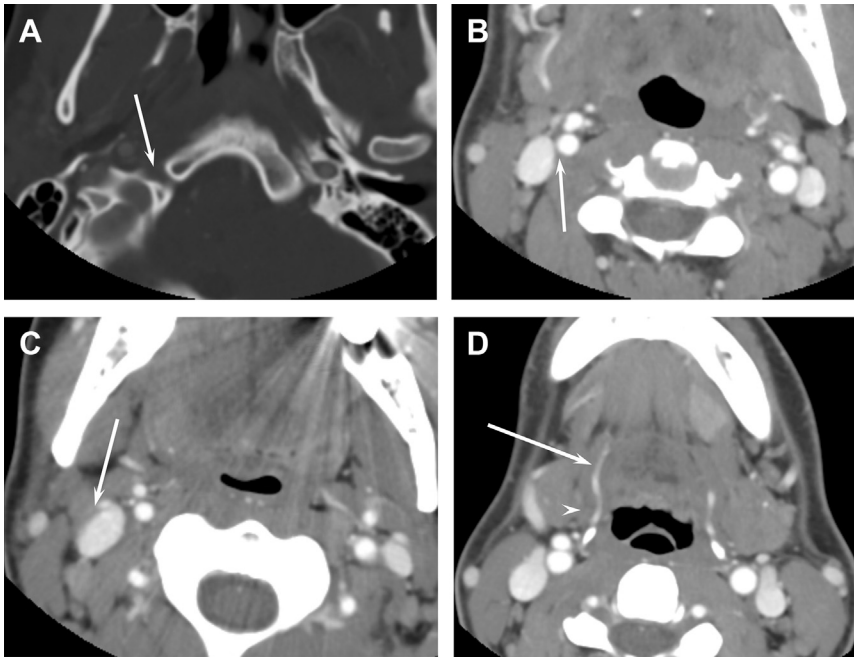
Cervical course of hypoglossal nerve. Axial CT images with arrows showing the expected course of CN XII through (A) hypoglossal canal; (B) carotid space posterior to the vessels; and (C) medial aspect of posterior belly of digastric muscles, along with the occipital artery and (D) crossing the lingual artery and curving anteriorly along the surface of the hyoglossus muscle (*arrowhead*), lateral to the lingual artery within the sublingual space.
